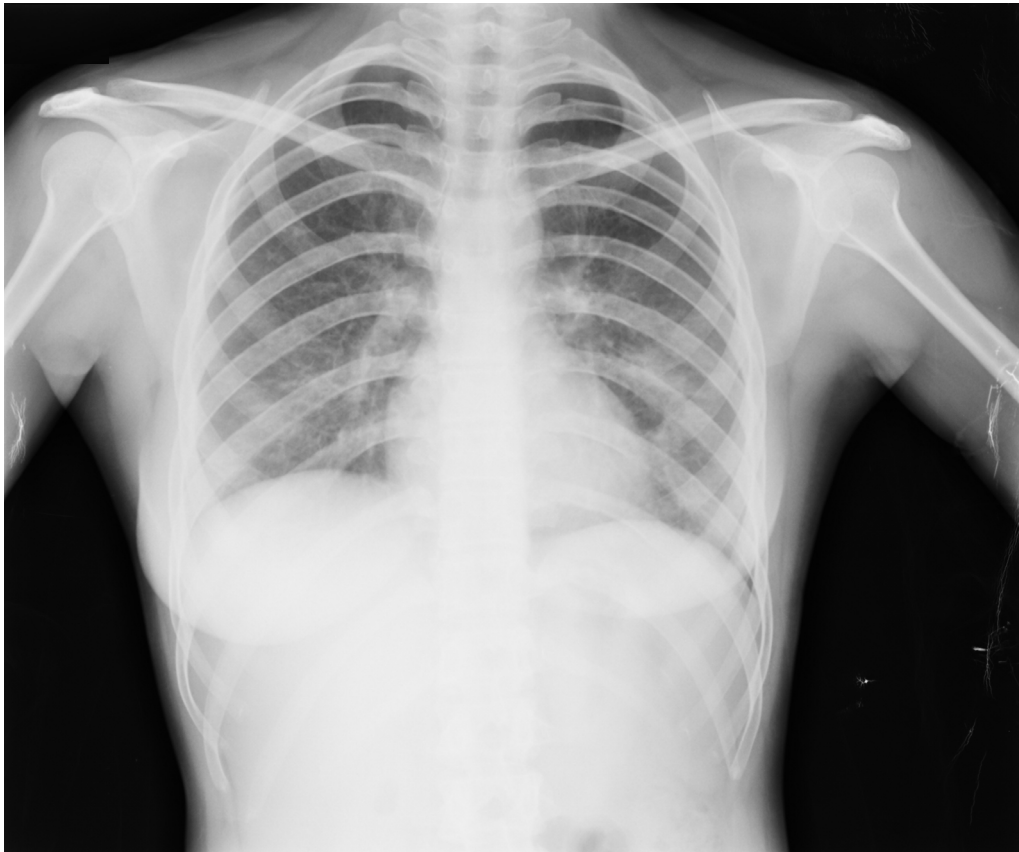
Chest radiograph showing resolution of opacities.
